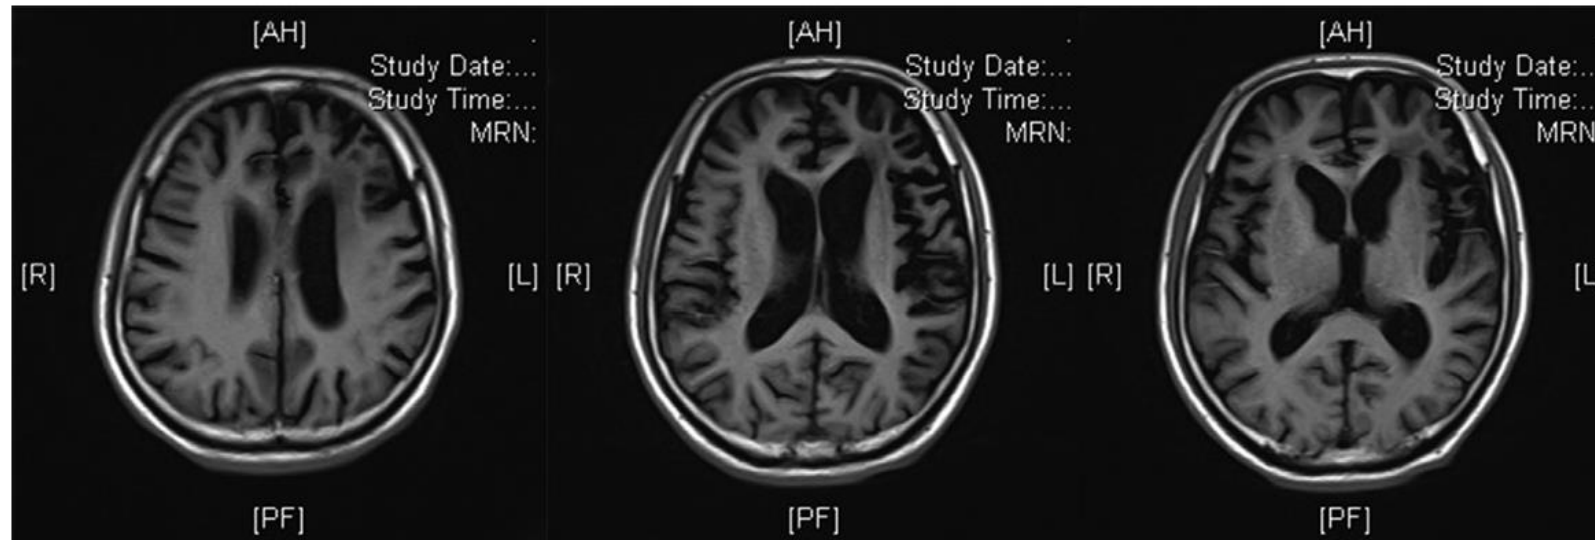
Brain MRI of the proband carrying *TARDBP* p.K176I mutation. T1-weight MRI of the brain revealed obvious atrophy of the cerebral, especially in the frontal and temporal lobes.
